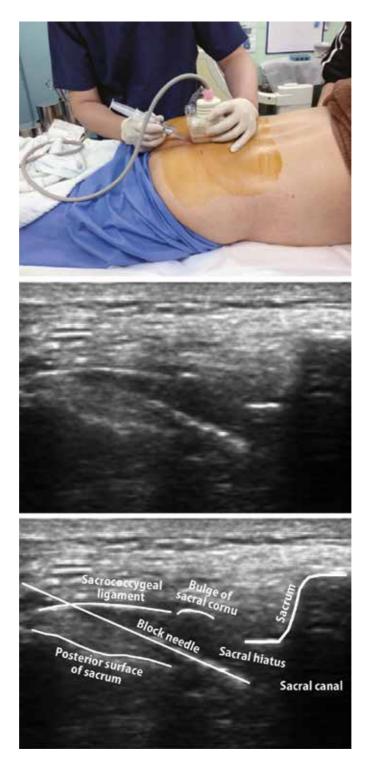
Ultrasound probe positioning and ultrasound images obtained during performance of caudal block.
